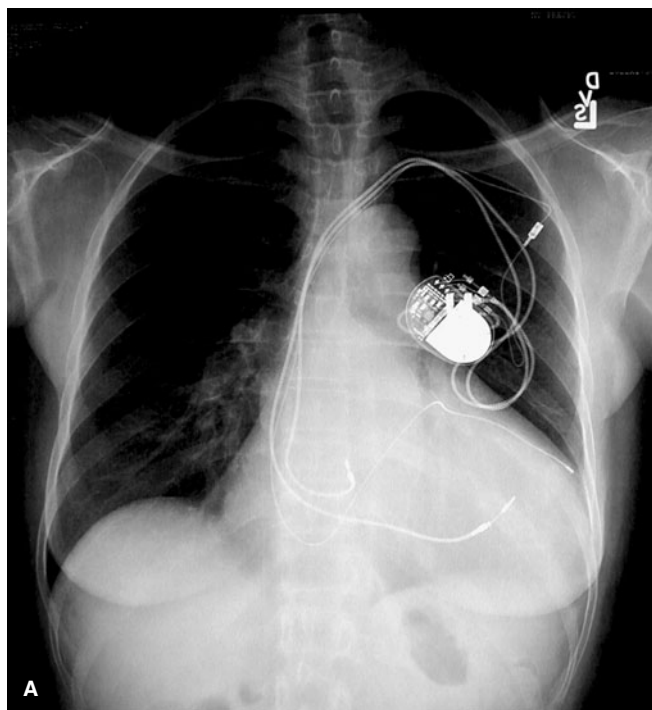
(A) Biventricular, dual-chamber pacemaker with endocardial leads in the right atrium, right ventricle, and lateral branch of the coronary sinus (left ventricle). This patient was relieved of dobutamine dependence by addition of the left ventricular lead. (B) Lateral x-ray of the same patient. The posterior course of the coronary sinus is apparent.
